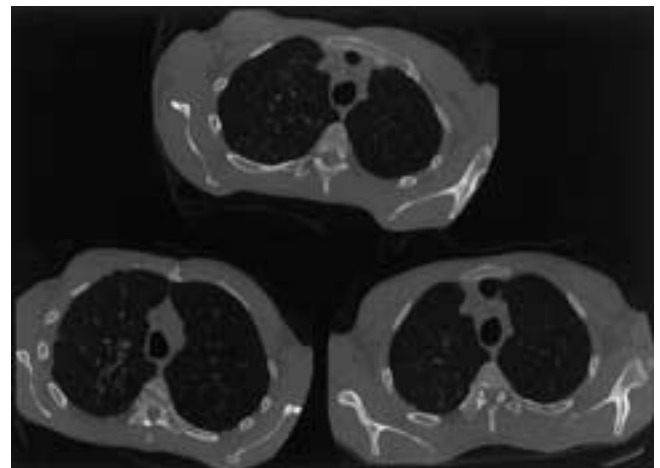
Tracheomegaly. Nonenhanced axial CT scan, obtained at three levels in the upper thorax, demonstrates marked dilatation of the trachea in this patient with recurrent pneumonia. Note that above the level of the aortic arch, the tracheal diameter is greater than 2 cm.
